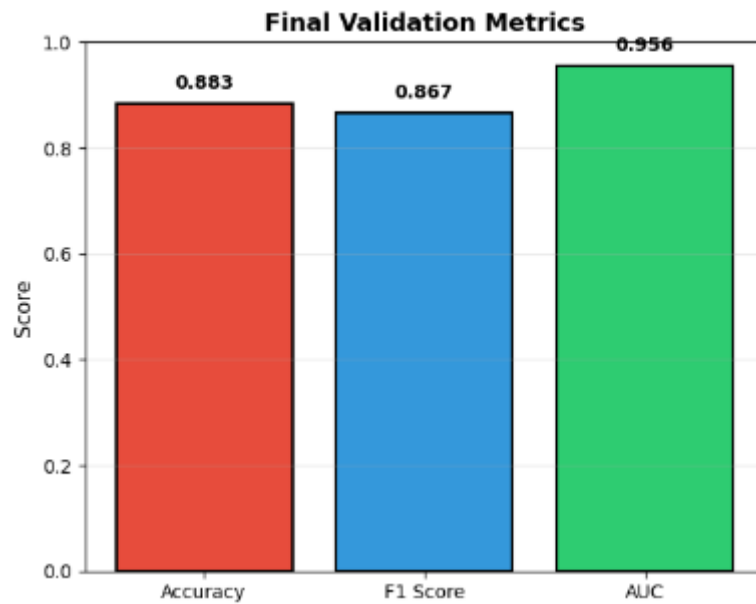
Ultrasound Training Curves - Validation Evaluation Metrics
